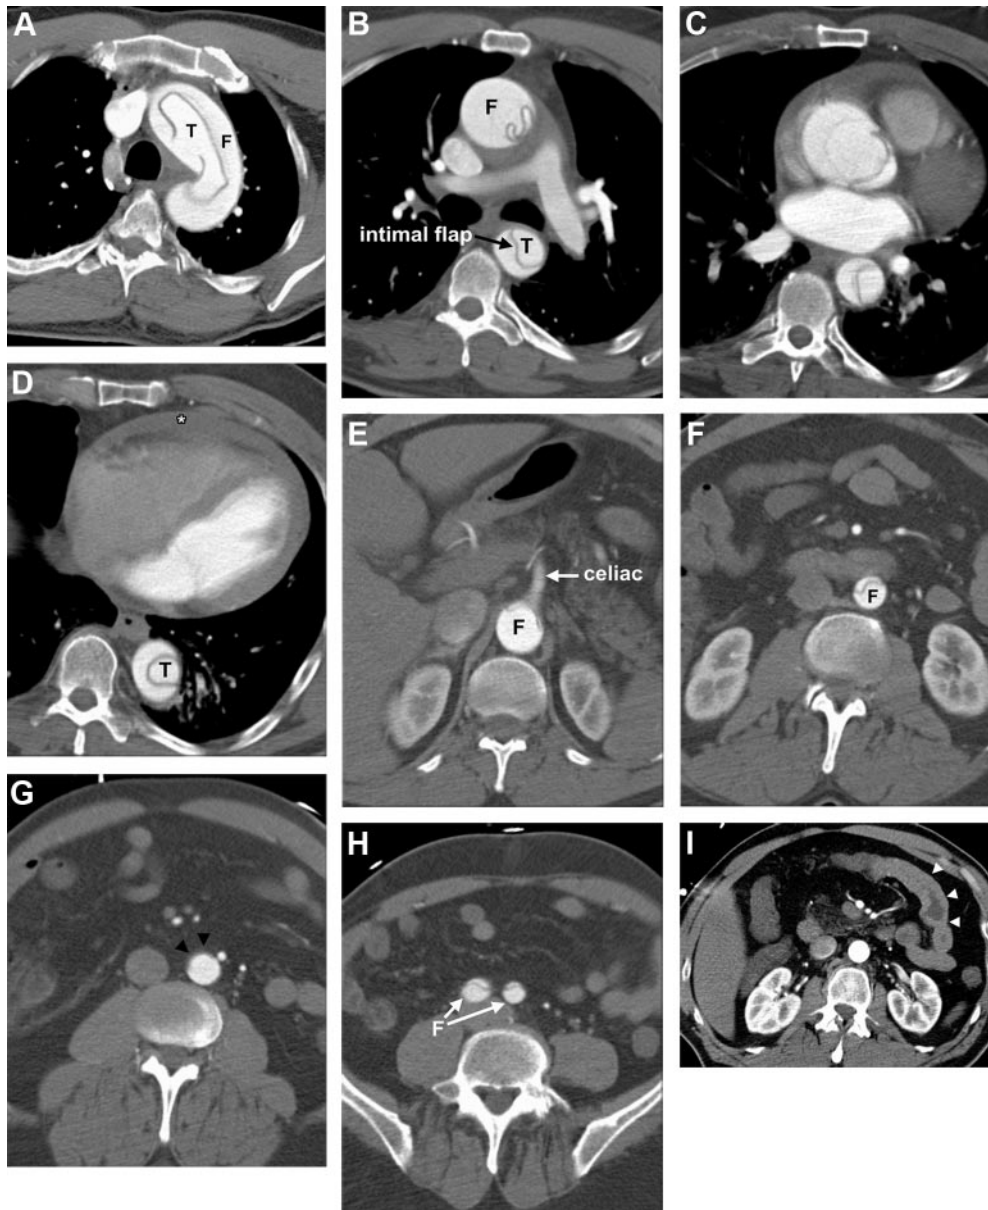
Type A aortic dissection and extent of involvement depicted on axial CT images from the cranial to caudal direction. Although the flap appears to disappear in the infrarenal, it is actually compressed against the anterior wall of the aorta in Panel G (arrowheads) and it is clearly present caudally in the common iliac arteries in Panel H. Hemopericardium (asterisk) is visible in Panel D. Bowel wall thickening (arrowheads) indicates ischemia in Panel I. Panel A, Aortic arch. Panel B, Mid thorax. Panel C, Aortic root. Panel D, Just above the diaphragm. Panel E, At the level of the celiac axis. Panel F, Mid kidneys. Panel G, Infrarenal aorta. Panel H, Proximal common iliac arteries. Panel I, Image through the mid abdomen at narrow window/level settings demonstrates small bowel wall thickening due to bowel ischemia caused by apposition of the flap against the origins of the celiac axis and superior and inferior mesenteric arteries. CT indicates computed tomographic imaging; F, false lumen; and T, true lumen.
